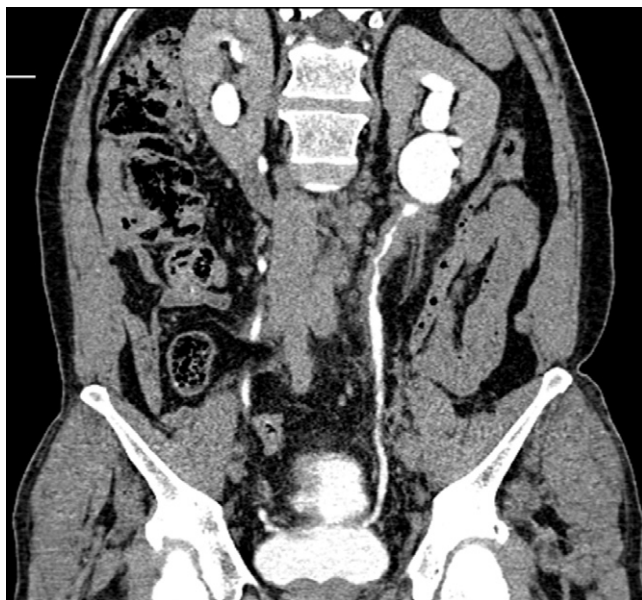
CT of the abdomen and pelvis, showing an extensive left peri-ureteric mass.
